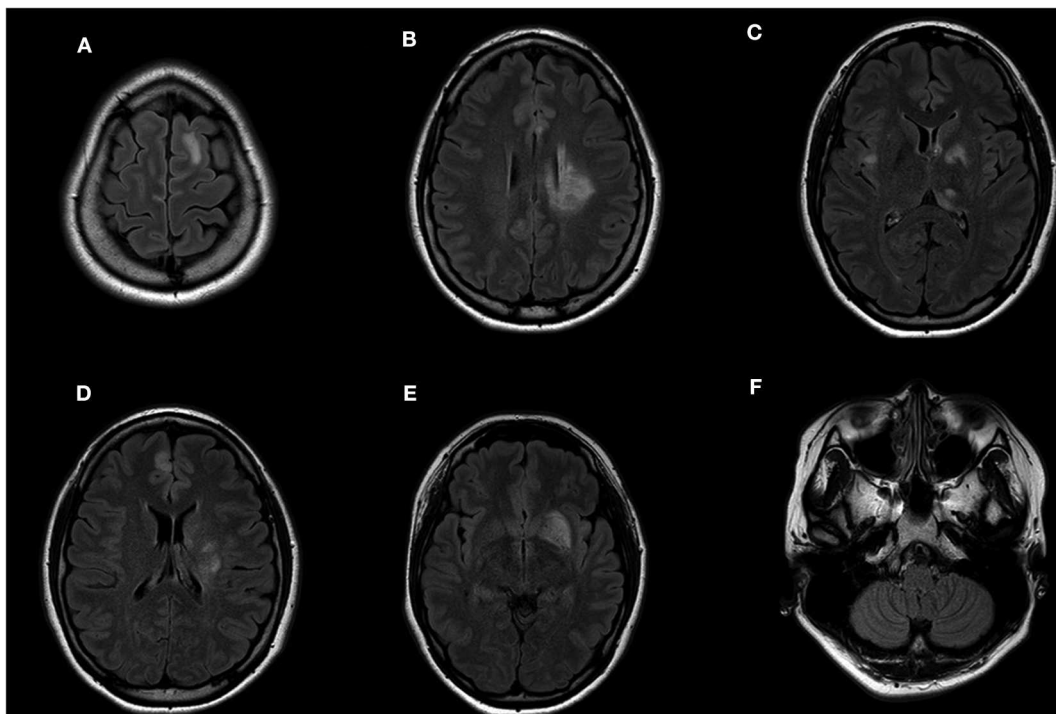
Participant 2 had high FLAIR signal abnormalities in the (A) left frontal lobe, (B–E) basal ganglia, (C) thalamus, right external capsule, and (D) right frontal lobe. (F) No area postrema lesion is observed.
